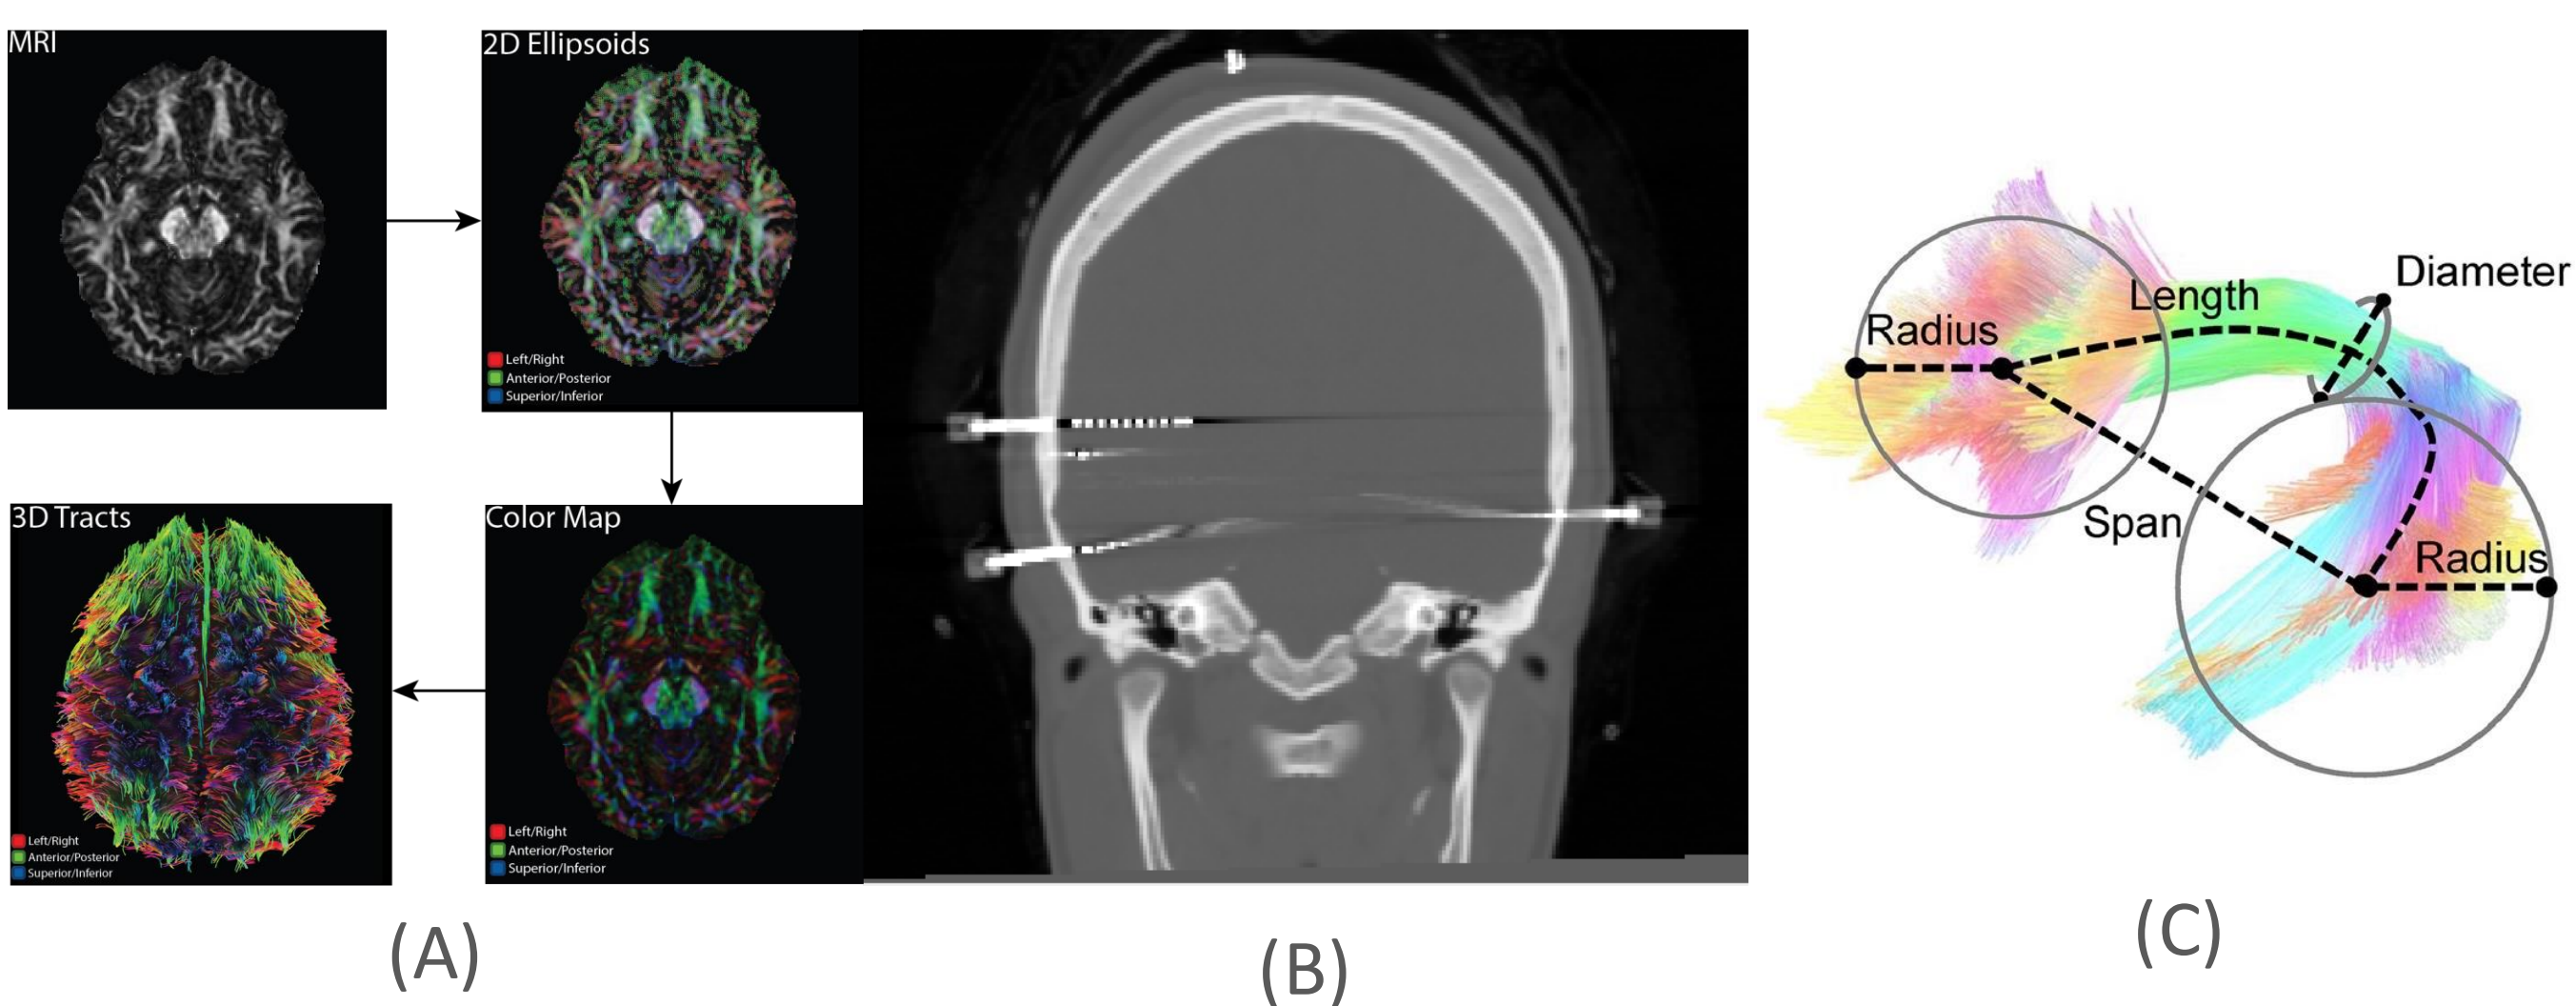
(A) Images showing process of model generation from MRI imaging to FA color mapping to 3D tracts. (B) Post-operative CT scan showing depth electrodes within cranium prior to segmentation. (C) Visualization of a few of the shape metrics displayed on a representative fiber bundle. (Figure from Yeh, 2020)²
